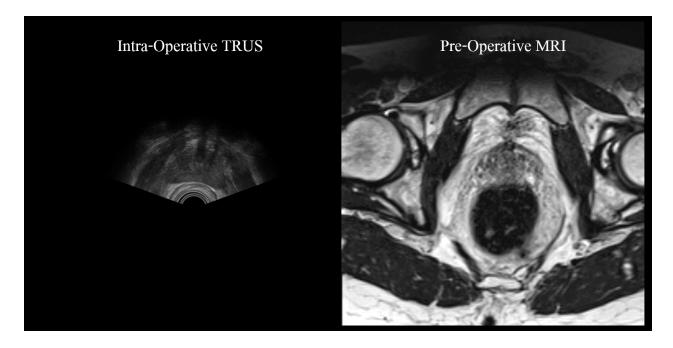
An intraoperative Transrectal Ultrasound (TRUS) image (Left) of the prostate and it's pre-operative MRI (Right) at the mid gland level. Unlike TRUS image the anatomical areas for example zonal anatomy can be well distinguished on MRI.
